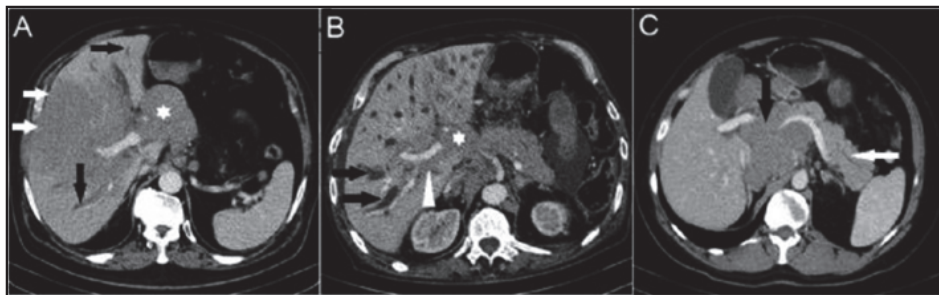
(A, B) Contrast-enhanced axial CT image revealed large hypodense lesion within right hepatic lobe (white arrow) and periportal hypodense areas (arrowhead). Dilatation of intrahepatic bile ducts (black arrow) and lymphadenopathies in the hepatic hilum (star) were viewed. (C) A CT scan demonstrated dilated pancreatic canal (white arrow). Also there were conglomerated lymphadenopathies which invaded head of pancreas (black arrow).
